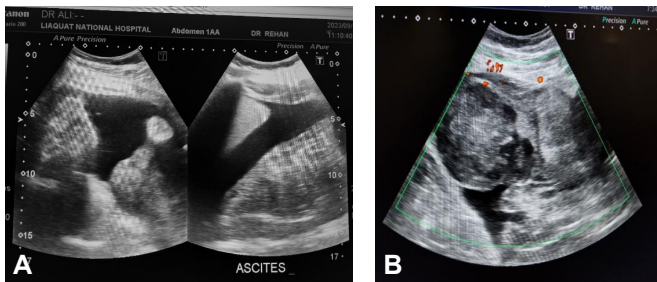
Ultrasound images of ascites and a heterogeneous area with internal vascularity.
